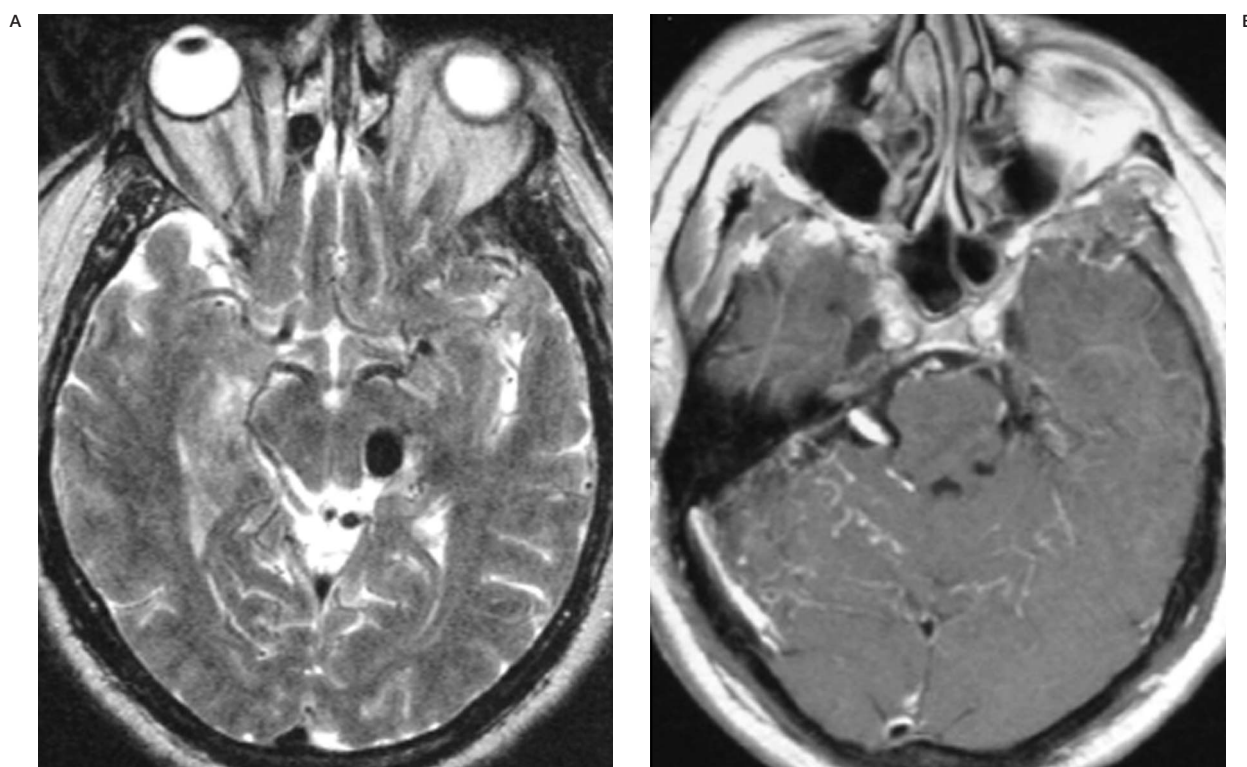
A) T2-weighted axial magnetic resonance (MR) image shows a venous aneurysm in the left perimesencephalic cistern which is indenting the left midbrain. B) Gadolinium-enhanced T1-weighted axial image shows a venous aneurysm in the right cerebellopontine angle near the trigeminal ganglion and multiple dilated serpiginous dilated vessels in the cerebellar hemispheres bilaterally which are clustered in the region of the tentorium.
